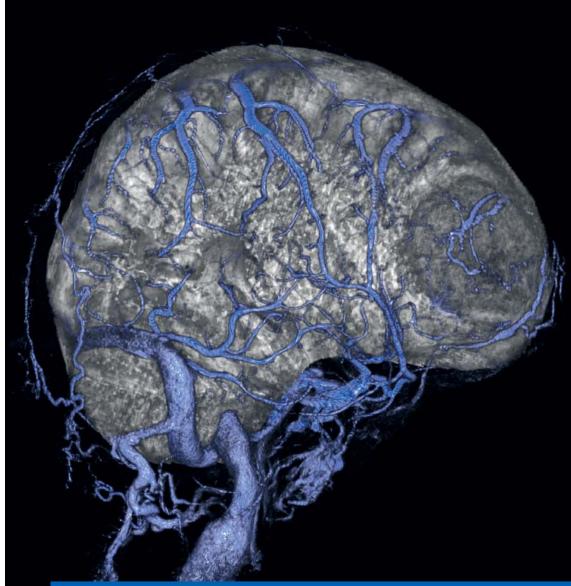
Image Fusion with MRI and Angiographic Data Sets to Reduce Radiation Dose "Pioneering into new fields and exploring new applications for interventional imaging is the driving force for our innovations – for our customers, their patients and advancements in medicine."
